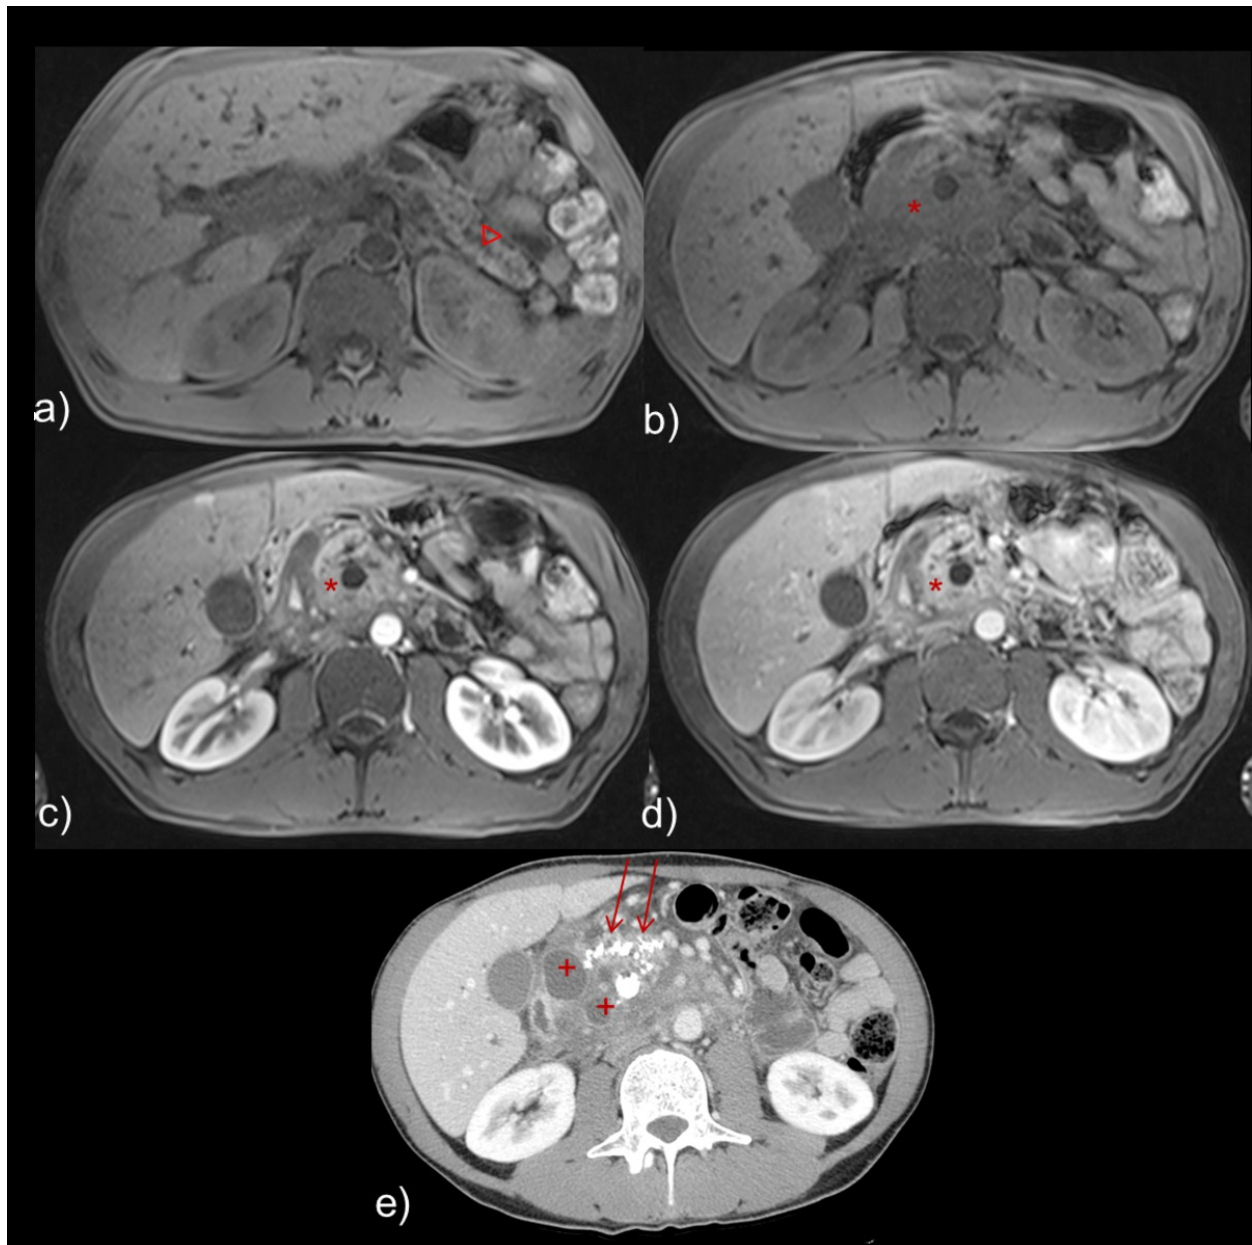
Axial T1 3D fat saturation non-enhanced images a) b), axial T1 3D fat saturation enhanced images c) d), enhanced axial CT image in portal venous phase e) - Another patient with an irregular main pancreatic duct dilatation (arrowhead) and a hypointense mass at the pancreatic head and isthmus (*), enhancing progressively, also diffusion weighted imaging disclosed restricted diffusion with low ADC (not shown). At CT examination the patient presented several parenchymal and intraductal pancreatic calcifications (arrow) and also pseudocysts (+), findings favoring chronic pancreatitis.
